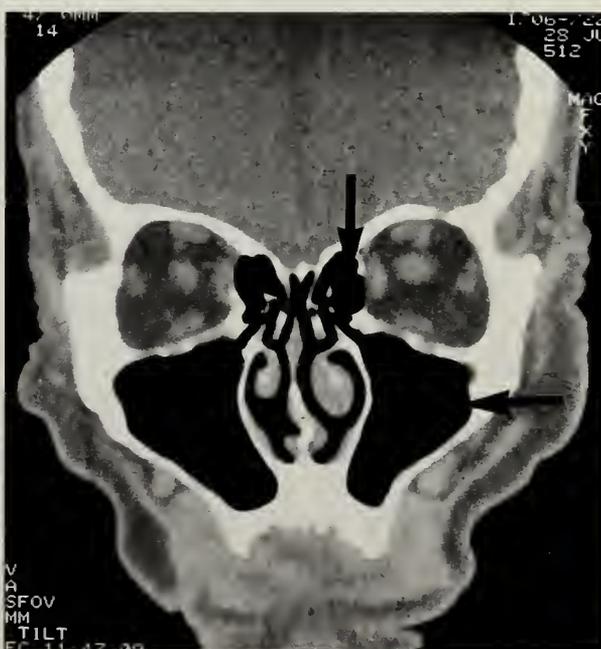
A computed tomographic scan shows a normal maxillary sinus (lower arrow) and ethmoid sinus (upper arrow).
